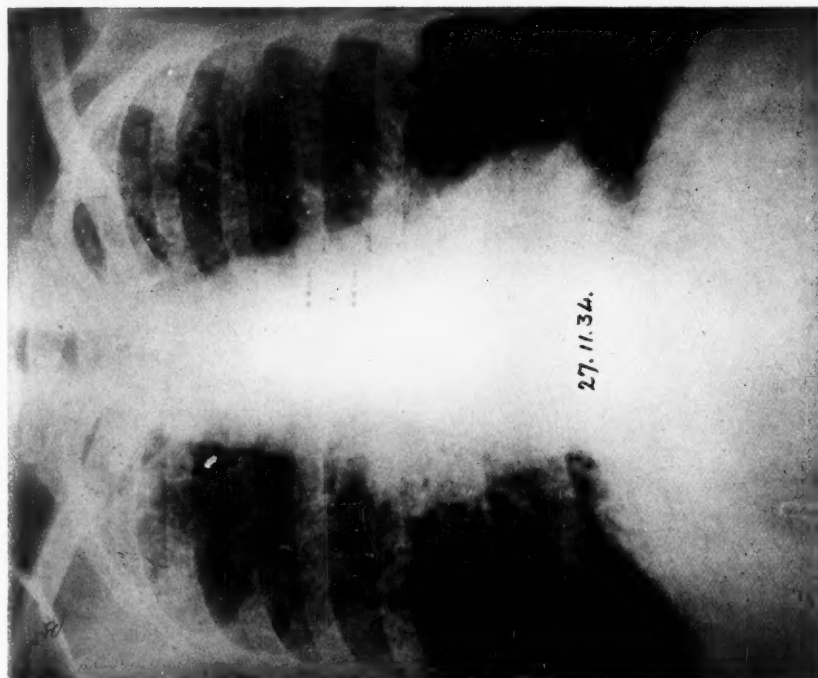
Case 1. X-ray of chest before operation
